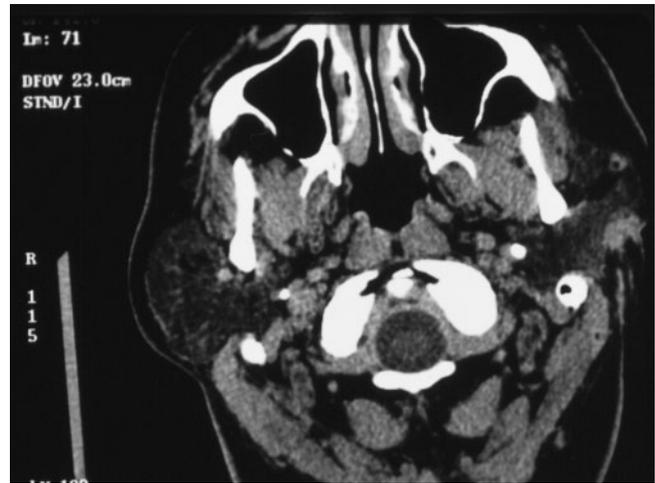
This is an axial view of a CT image soft tissue window demonstrating a tumor of the right parotid. Courtesy of Dr. Mel Mupparapu, University of Pennsylvania.
